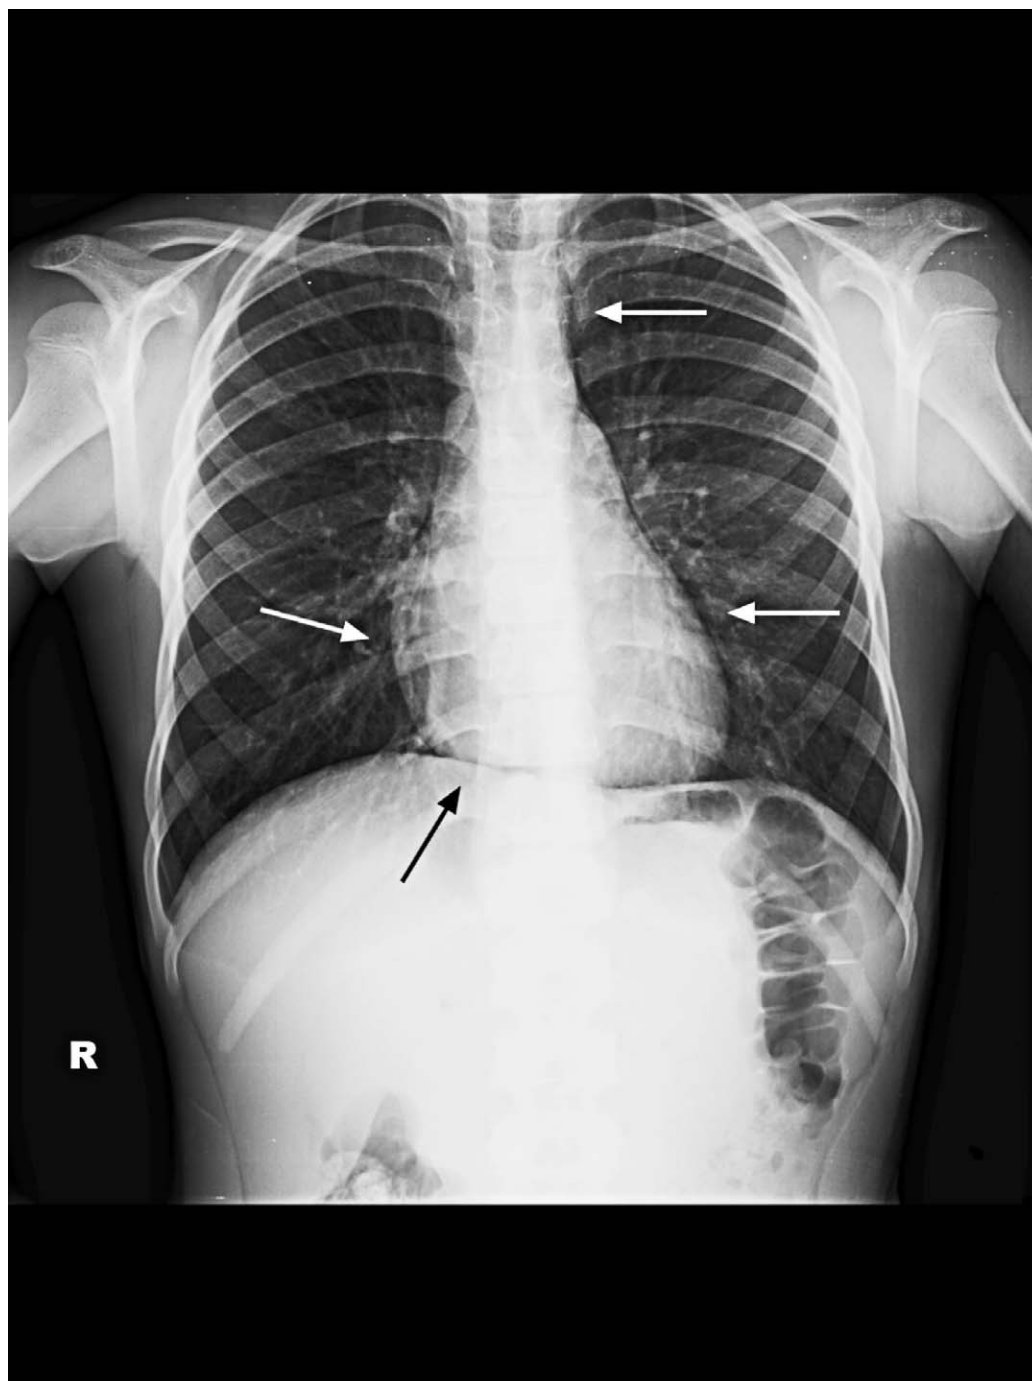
Anteroposterior chest radiograph shows gas outlining the inner surface of the mediastinal pleura (white arrows) and a thin band of gas between the heart and diaphragm (continuous diaphragm sign; black arrow).
